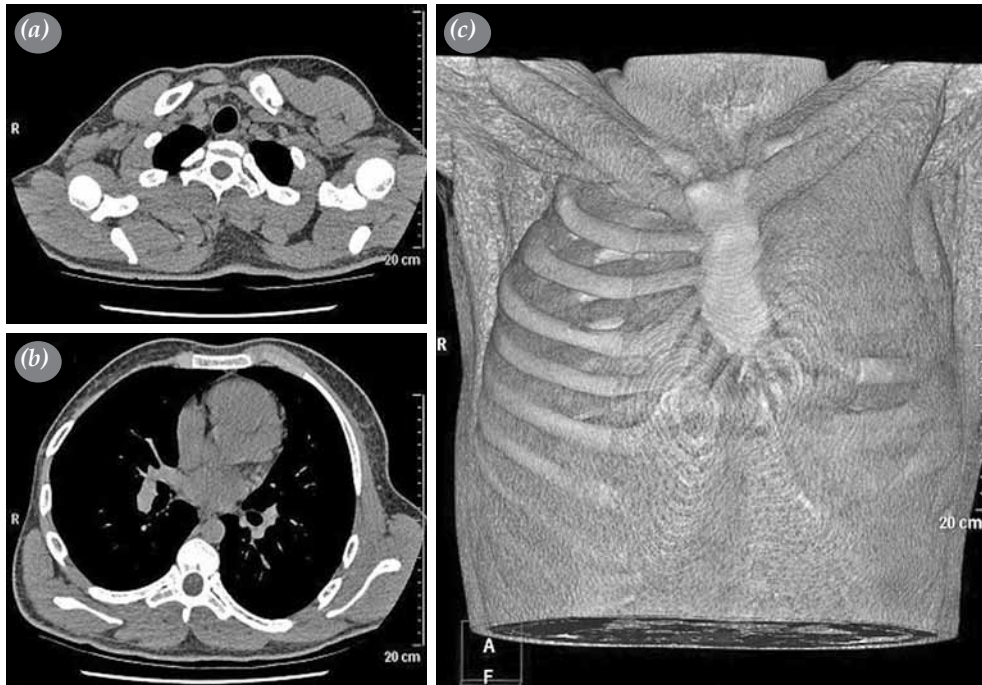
(a) Axial noncontrast-enhanced computed tomography showing the absence of the sternocostal head of the right pectoralis major muscle and the hypoplasia of the right pectoralis minor muscle. (b) Axial noncontrast-enhanced computed tomography showing the absence of the right serratus anterior muscle and the hypoplasia of the right scapula. (c) Three-dimensional volume rendering showing the absence of the sternocostal head of the right pectoralis major muscle along with the absence of the right serratus anterior muscle.
